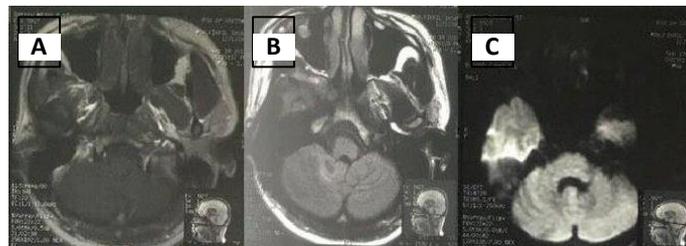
The brain MR-imaging in the T1-weighted image (A) did not show a ring-enhancing mass in the right cerebellar hemisphere, but in the FLAIR sequence (B) revealed the perifocal edema in the right cerebellar hemisphere could be caused by post-infection. The DWI sequence (C) revealed an unrestricted diffusion area.
